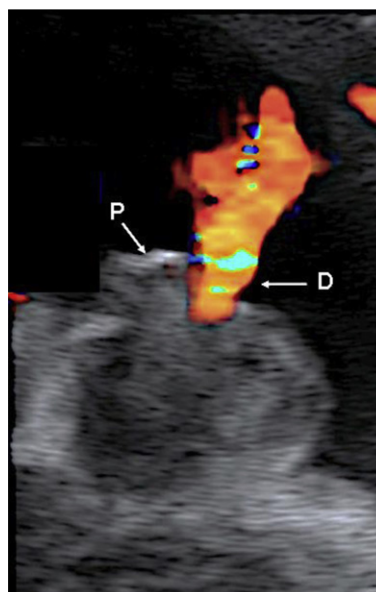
Doppler ultrasound showing urinary flow from a proximally placed urinary orifice (D) at the base of the short phallus (P). (Courtesy F Ushakov, London).
